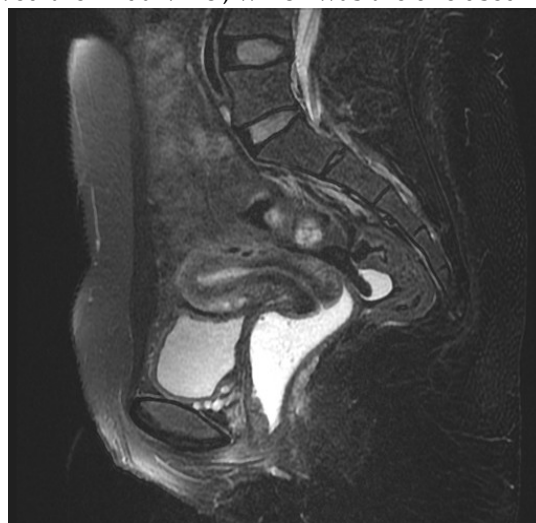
Cervical tumor seen on MRI.
